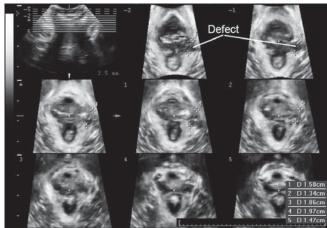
Quantification of trauma on multislice/tomographic ultrasound imaging. There is a typical left-sided levator defect measuring about 2 cm in (dorsoventral) width and at least 1.25 cm in (craniocaudal) depth as it is apparent in at least five slices.
